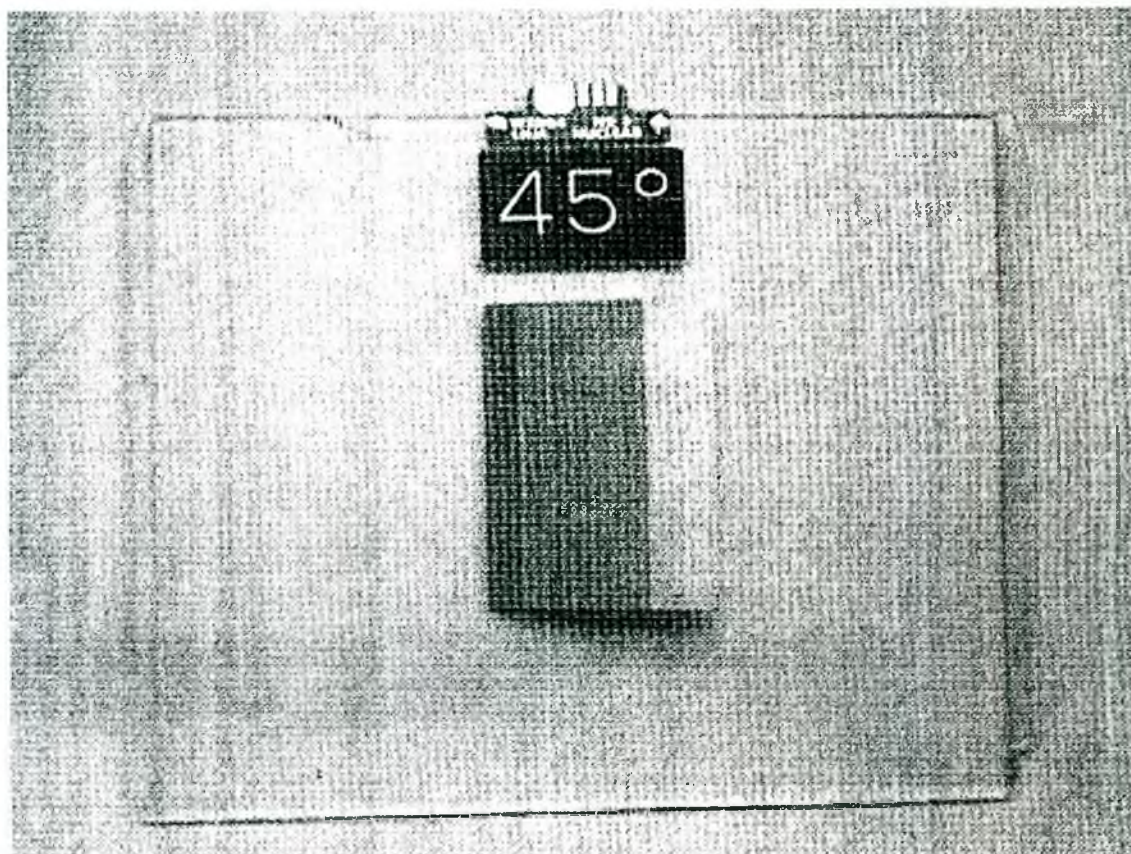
Photograph of a 45° wedge filter for a 4-MV x-ray linac.
